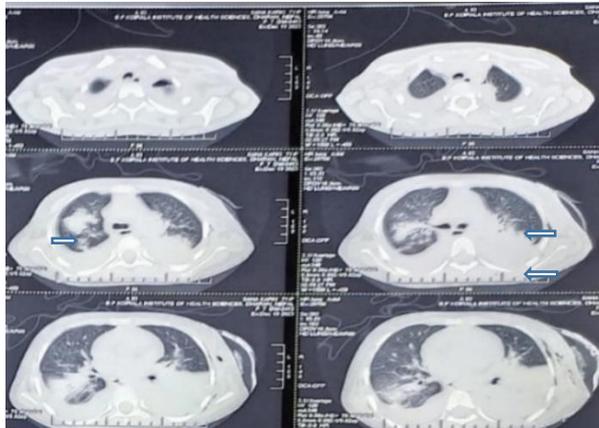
CT chest showing right middle zone opacity and left-sided opacity (hemothorax)
